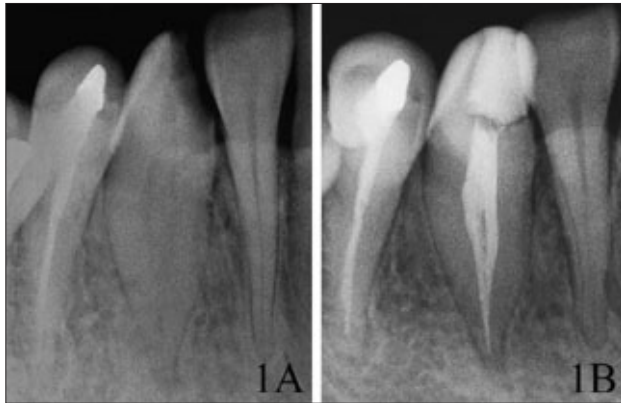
Case 1: (A) preoperative radiograph of tooth 43 shows two root canals; (B) final obturation of the root canals using cold lateral condensation.
